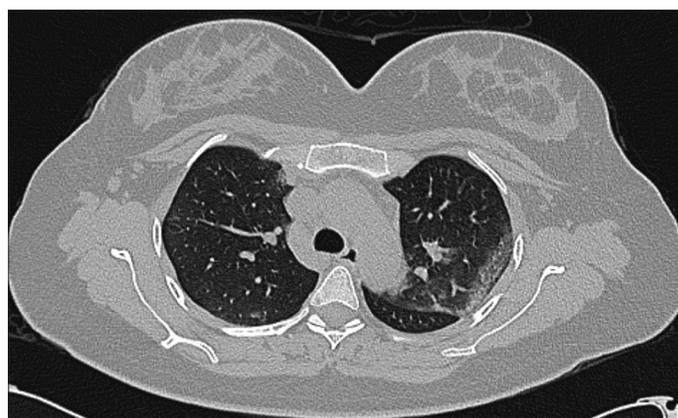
Chest computed tomography. An axial section through the upper lung (lung window) shows left upper lobe peripheral ground glass opacifications along with subtle intralobular septal lines.
